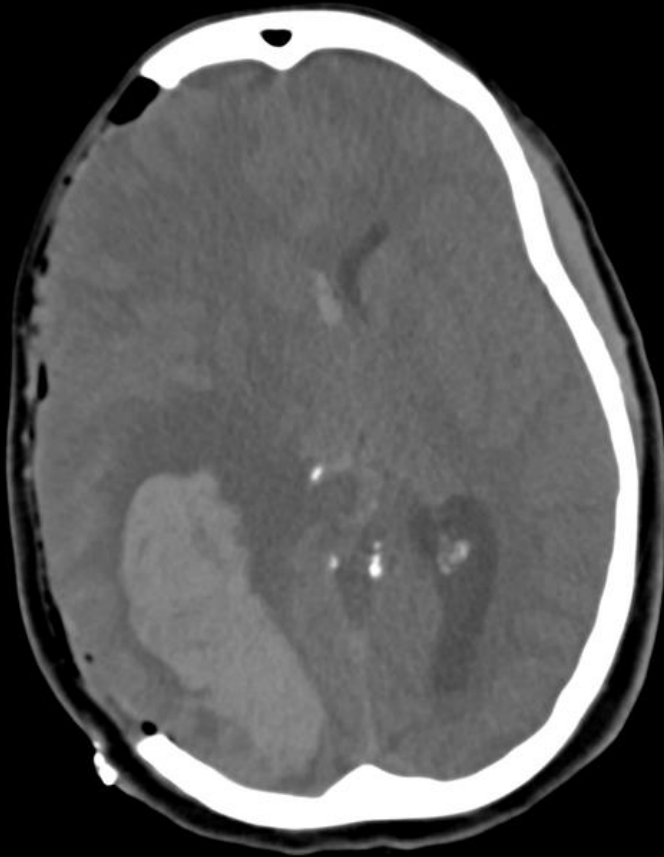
Non-contrast CT head at level of pons (not seen in our patient)
